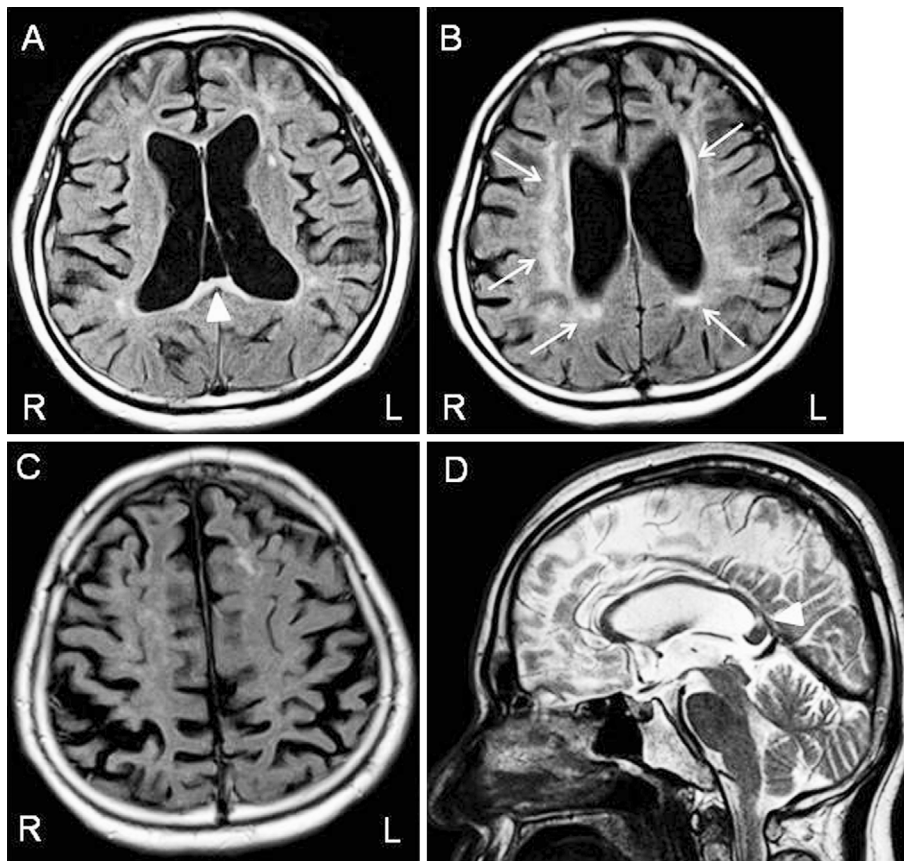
Brain MRI images. Brain MRI images of the patient (at 41 years of age) are shown. Dilatation of the lateral ventricles and hyperintense foci are observed in the cerebral deep and periventricular white matter on FLAIR-weighted images (arrow, A-C). The corpus callosum is atrophic and shows high signal intensity in the splenium (arrowhead) on FLAIR-weighted (A) and T2-weighted images (D).
